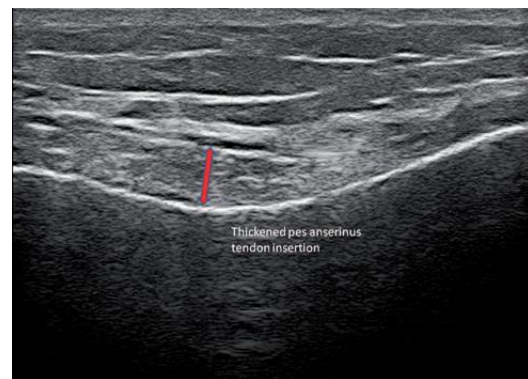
PAT: The PA tendon insertion is thickened. Retrived from: Toktas H, Dundar U, Adar S, Solak O, Ulasli AM. *Ultrasonographic assessment of pes anserinus tendon and pes anserinus tendinitis bursitis syndrome in patients with knee osteoarthritis. Mod Rheumatol. 2015 Jan;25(1):128-33.*
